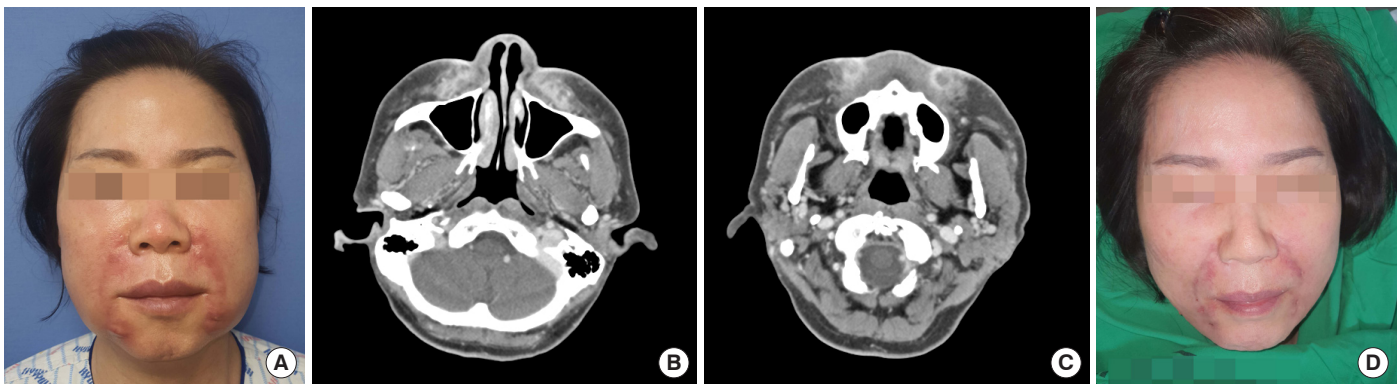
Recurrent delayed hypersensitivity reaction event. (A) Patient's photographs taken on the day of recurrence. Erythematous swelling recurred on both nasolabial folds and chin, more localized than the prior event. (B, C) Contrast-enhanced facial computed tomography shows a more heterogeneous pattern, with ill-defined soft tissue densities, suggesting aggravated cellulitis and abscess formation. (D) Patient's photographs taken 2 days after surgical drainage. Improved erythema and swelling are seen.
